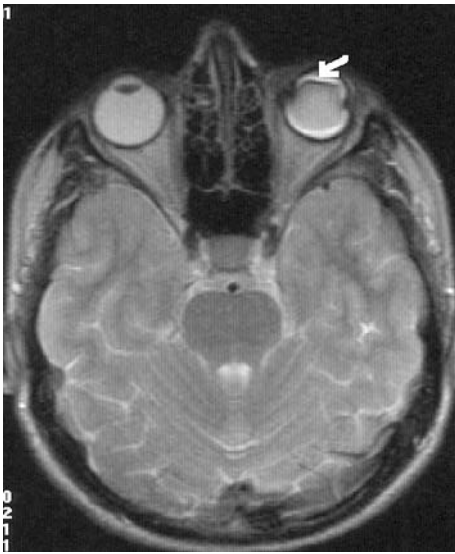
MRI image, T2 weighted. Silicone oil is present in the left orbit (*arrow*), showing a characteristic signal
